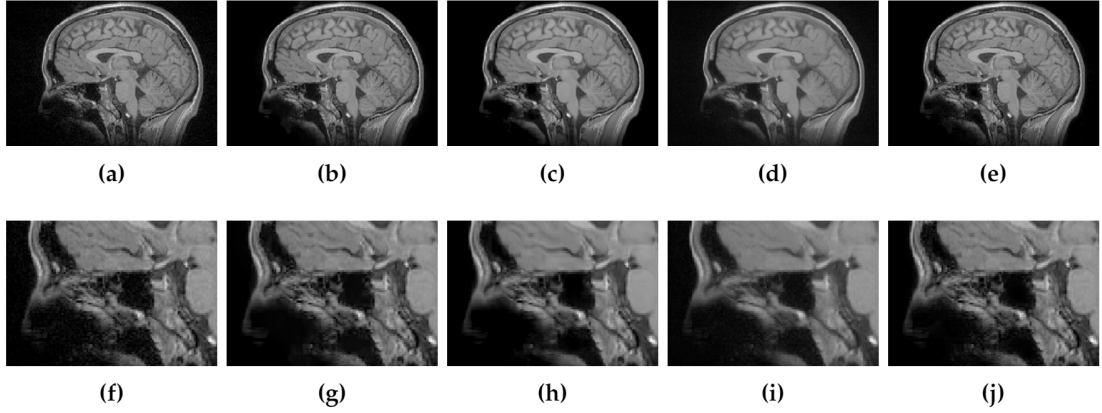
Quality comparisons on a real T1w MR image. (a) Original MR image, (b–e) denoising results of the PRINLM, the BM4D, the DnCNN, and the NLSD. (f–i) the corresponding zoom-in of figures (a–e).
